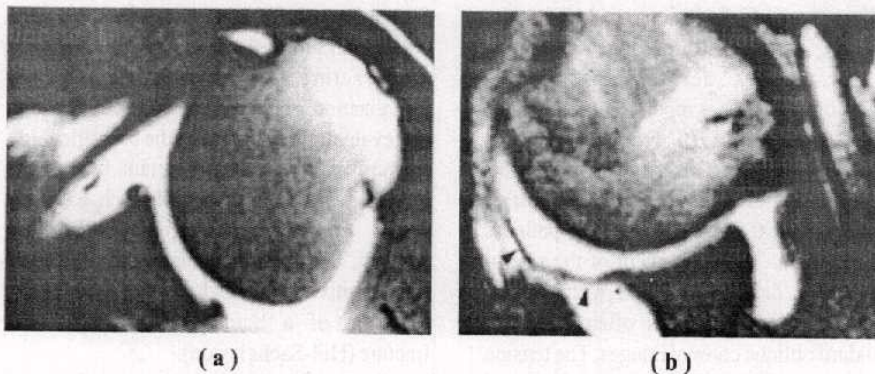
Detection of redundancy of the anterior capsule with the ABER position in a 24-year-old man who had atraumatic anterior shoulder subluxation. (a) Standard axial T1-weighted MR arthrogram showing no capsulolabral abnormality, (b) ABER oblique axial T1-weighted MR arthrogram revealing a redundant anterior capsulo-ligamentous complex (arrowheads), which could explain the patient's clinical condition. The anterior labrum (arrow) is intact.
